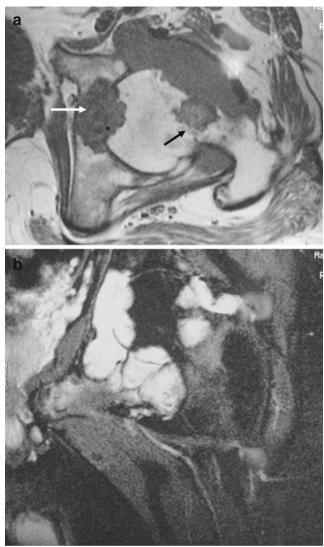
Axial T1-weighted (a) and coronal T2 fat-saturated (b) images of the left hip from an MRI demonstrating extensive lobular intraarticular soft tissue predominantly isointense to muscle on T1 and hyperintense on T2. There are multiple areas of erosion along both the femoral and acetabular joint margins. Note the area of central low signal within the central joint space on the axial image (*white arrow*) felt to reflect calcification and the more irregular and "permeative" border of the tumor with the bone along the anterolateral margin of the femoral neck (*black arrow*)
